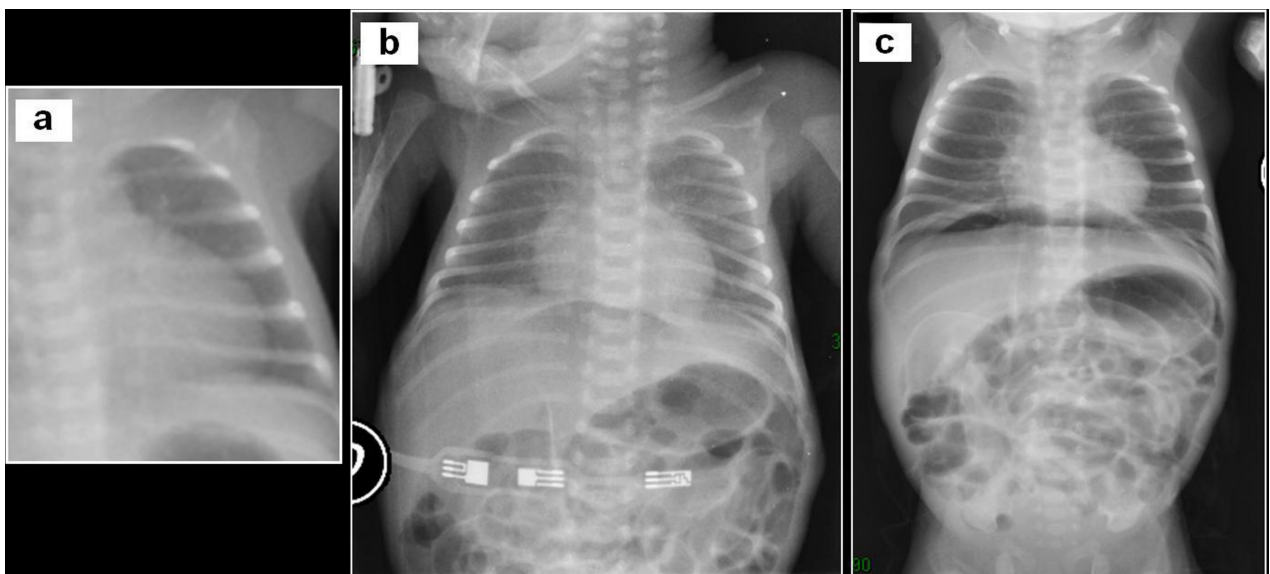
a) Thoraco-abdominal X-ray (TAX) after birth; b,c) TAXs on day of life 7
